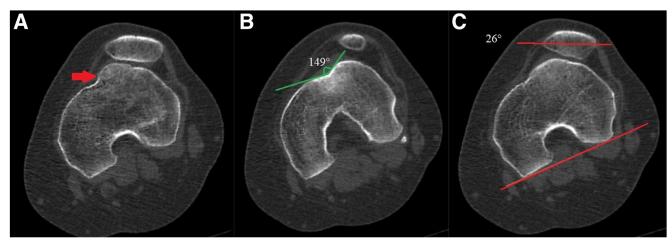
Left knee. A preoperative computed tomography, axial view, is shown. (A) Abnormal trochlear shape with supratrochlear spur and lateral bump (red arrow). (B) Sulcus angle of 149° (green angle). (C) Patellar tilt of 26° (red lines) and a lateralized patella.
